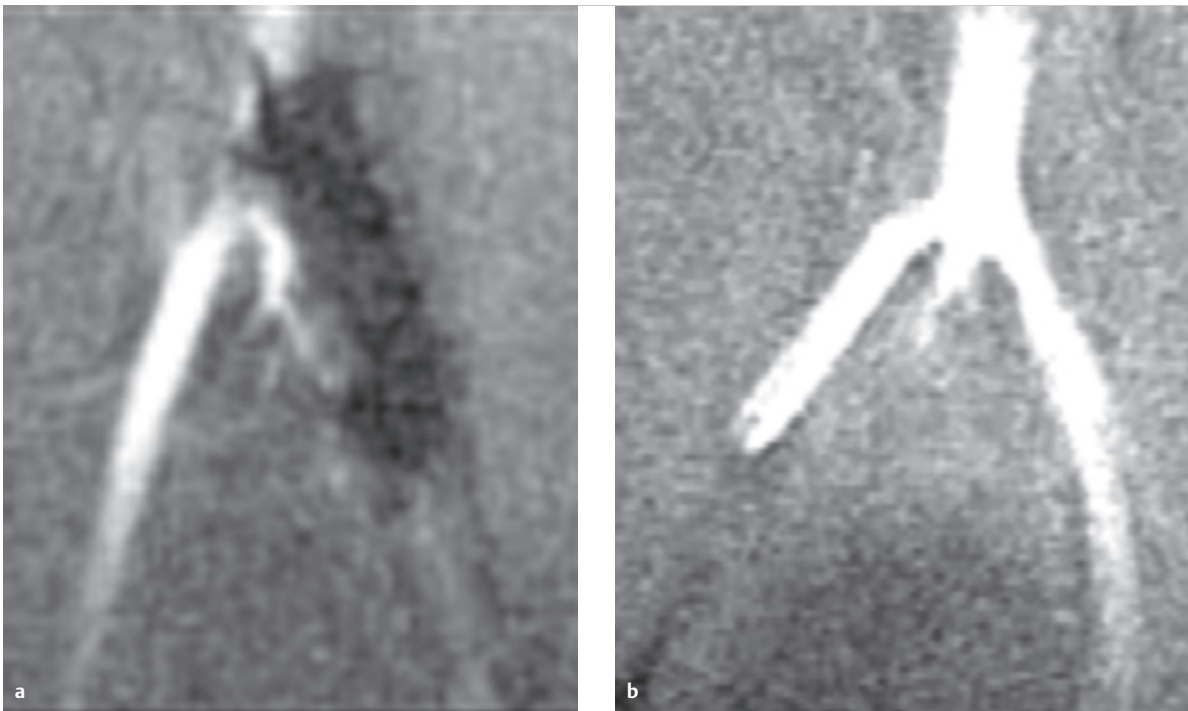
MRI depiction of a balloon with radial k-space sampling.
